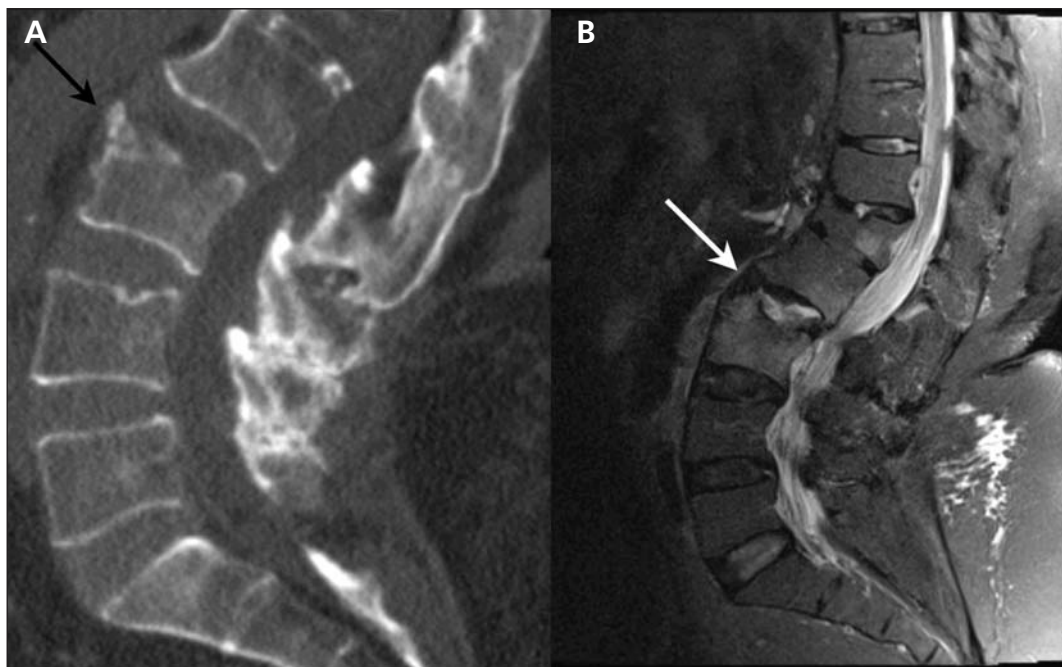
(A) Sagittal computed tomographic reconstruction of the spine of a 68-year-old woman with lower back pain showing erosive changes at the superior end plate of L3 (black arrow). (B) Sagittal T₂, fat-saturated magnetic resonance image showing fluid signal intensity within the L2/3 (white arrow) disk with high signal intensity in the adjacent vertebral bodies.
